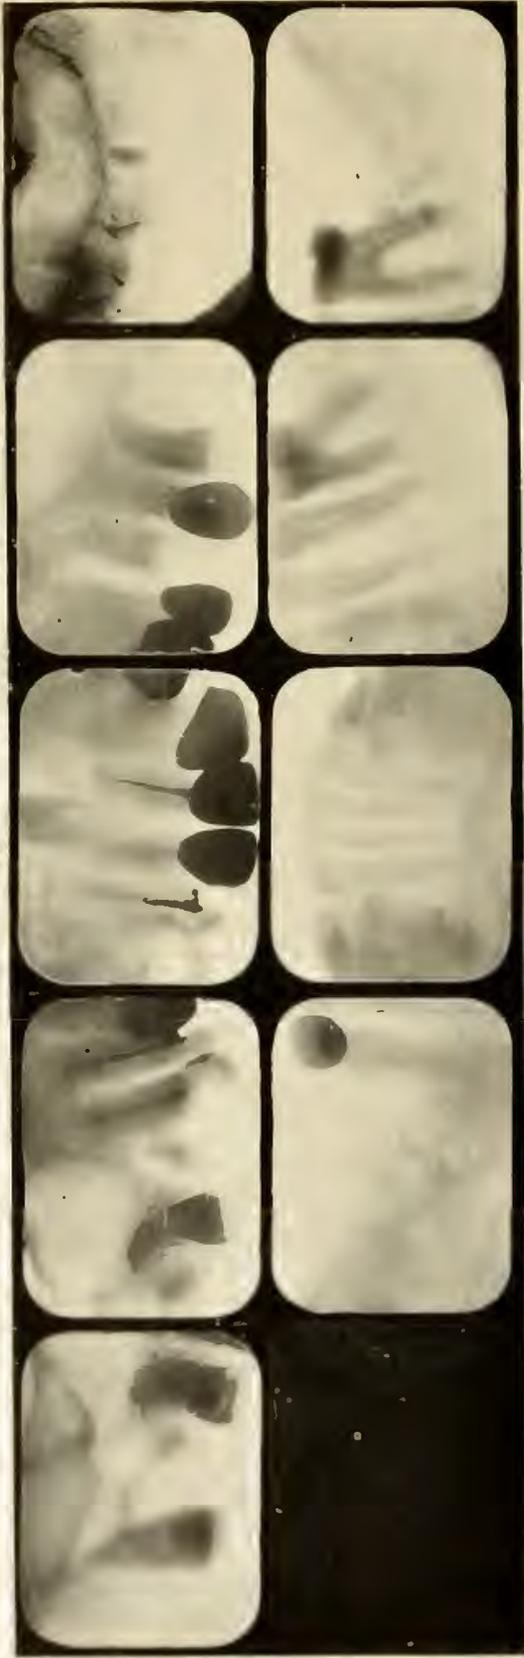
ROENTGENOGRAPHIC APPEARANCE OF TEETH OF CASE No. 965 WITH STOMACH AND NERVOUS DISTURBANCE.
